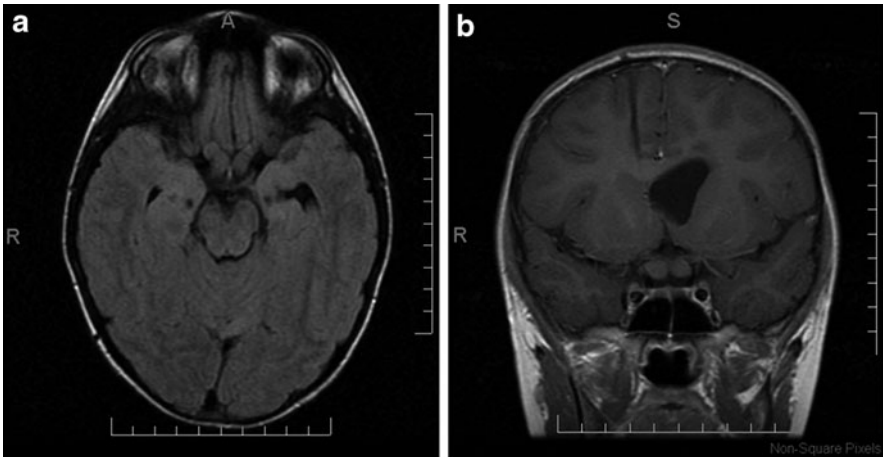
MRI glioma optic chiasm: (a) axial and (b) coronal
